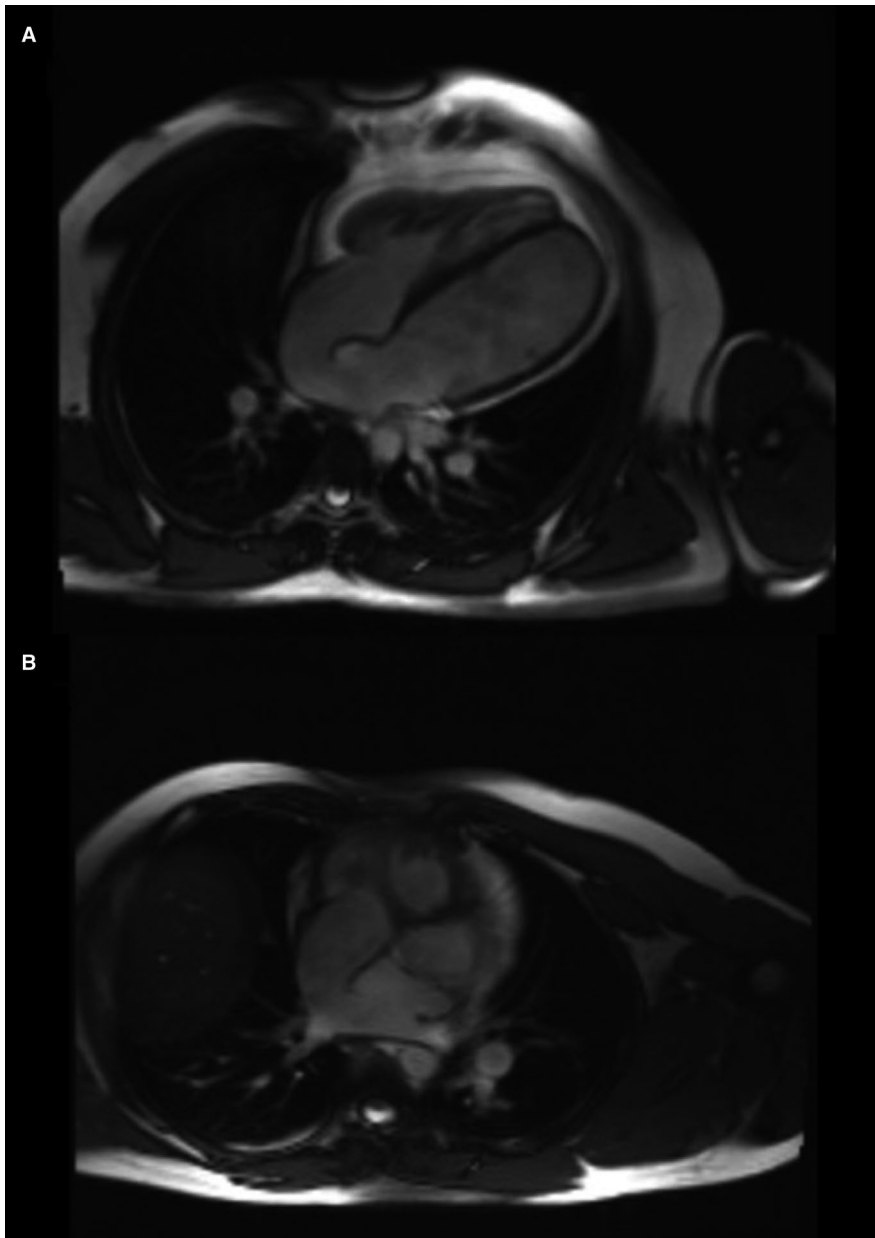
Appearances of baffle leak as demonstrated on the cardiac MRI. A, four chamber view with significant sized baffle leak and moderate to severe left ventricular dilatation. B, Para-axial view demonstrating the significant leak and unobstructed pulmonary venous baffle
